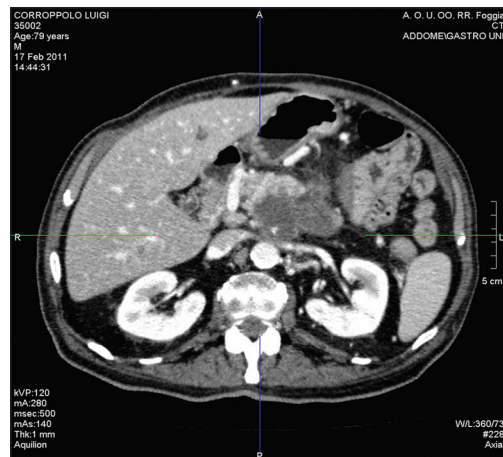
Tumor response assessed by means of computed tomography (CT) 48 h after the procedure
